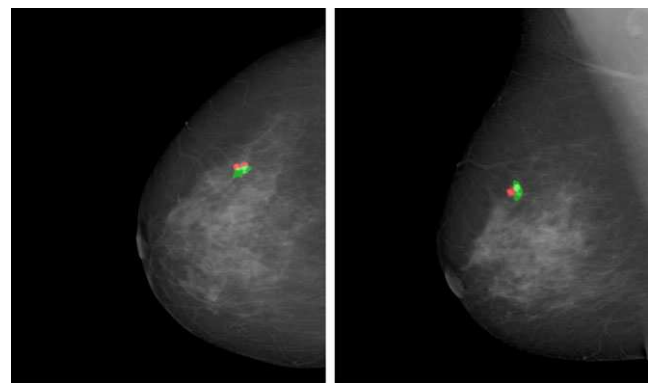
CC and MLO mammograms of the same breast. The red area corresponds to the suspicious regions in the mammograms, while the green area represents the location of the MRI lesion, once the registration has been performed.
